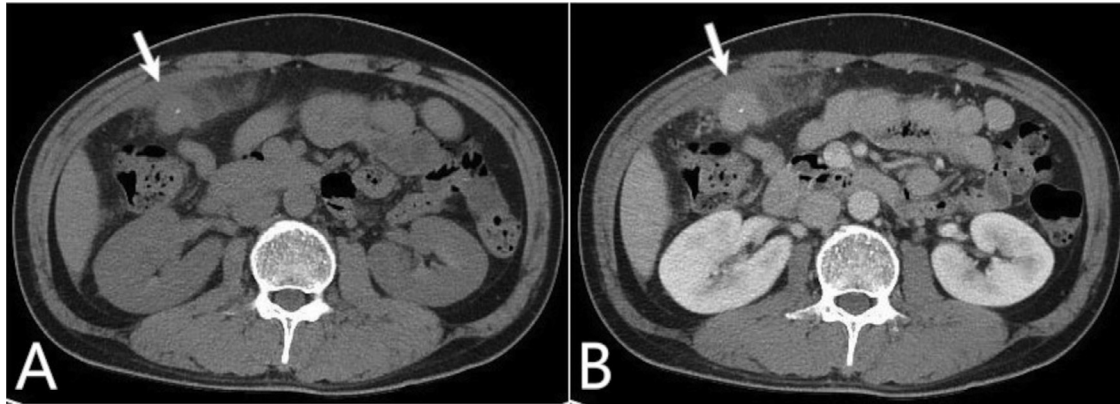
Axial computed tomography scans show a bright dot-like material with surrounding enhancing soft tissue density lesions and fat infiltrates in the omentum located in the right upper quadrant (A, B, arrow).
